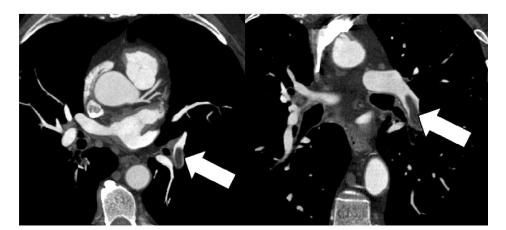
Acute pulmonary embolism (arrows) incidentally found in 58-year-old-woman who was referred for coronary CT angiography for atypical chest pain.
